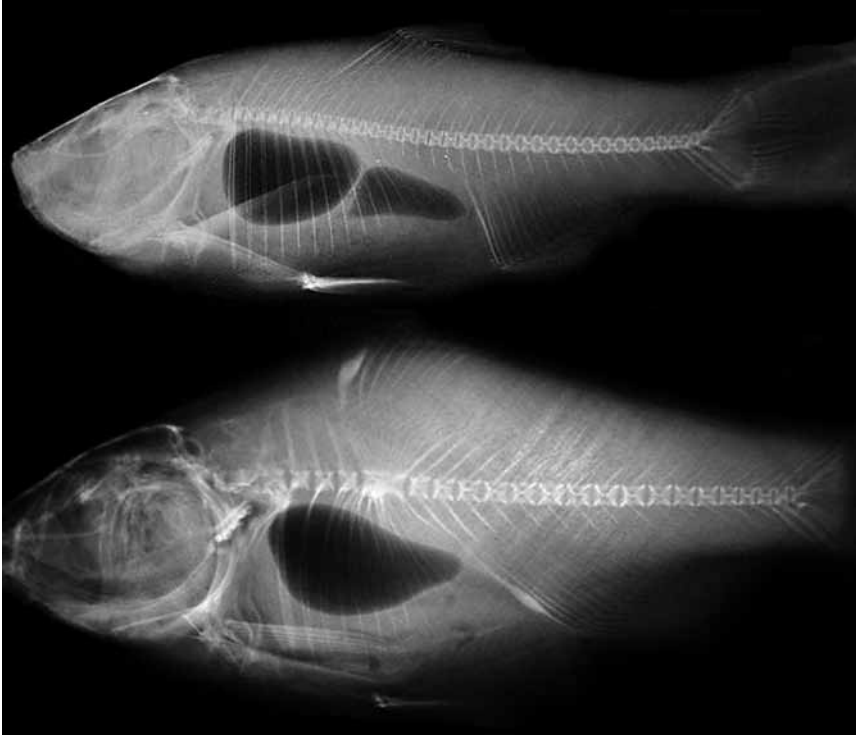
X-ray of bighead carp *Hypophthalmichthys nobilis*. Above: normal fish. Below: fish with skeletal deformity.
